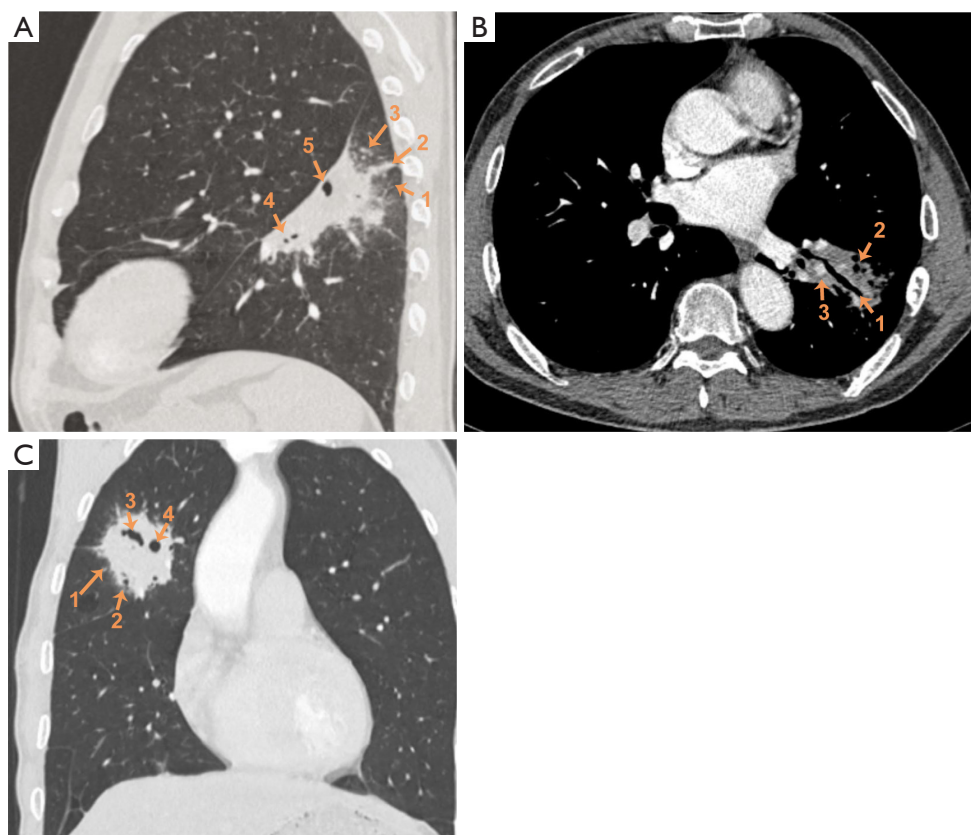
High-resolution computed tomography images of typical cases. (A) consolidation was observed in the lower left lung lobe, accompanied by a ground-glass opacity around the tumor (yellow arrow 1), thickening of bronchovascular bundles (yellow arrow 2), and peripheral micronodules (yellow arrow 3). Within the lesion, signs of air bronchogram (yellow arrow 4) and small air bubbles (yellow arrow 5) were also identified; (B) consolidation was observed in the lower left lung lobe. Within the lesion, there was evidence of bronchial dilation (yellow arrow 1) and signs of air bubbles (yellow arrow 2). After contrast enhancement, vascular imaging signs were visible within the lesion (yellow arrow 3); (C) a mass shadow was present in the upper right lung lobe, with the focal mass with spiculated contours and surrounded by ground glass opacity (yellow arrow 1). Within the lesion, there were signs of air bronchogram (yellow arrow 2), bead-like bronchial dilatation (yellow arrow 3), and small air bubbles (yellow arrow 4).
